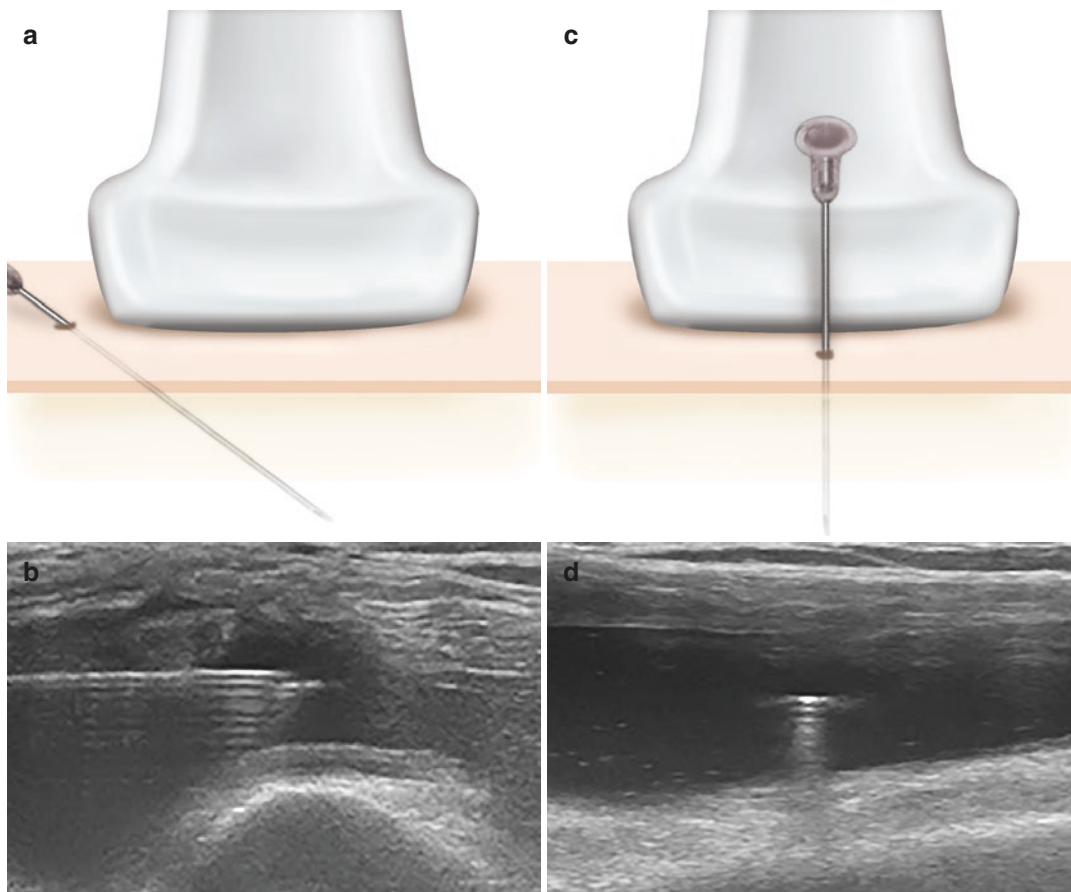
Methods of needle insertion into joints under ultrasonic guide. (a) In-plane needle placement. Long axis of the needle is located within the US scanning plane. (b) Needle can be seen on the US monitor in the long-axis
